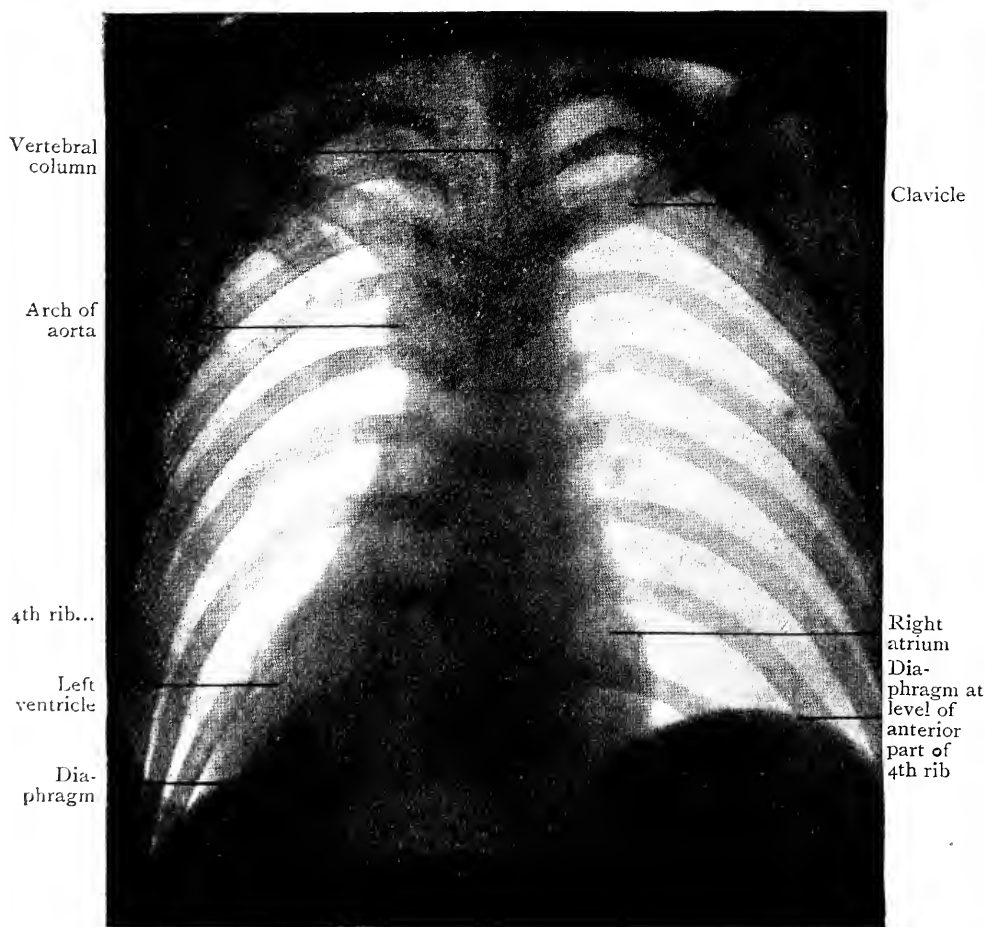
Radiograph of Thorax, seen from behind.
